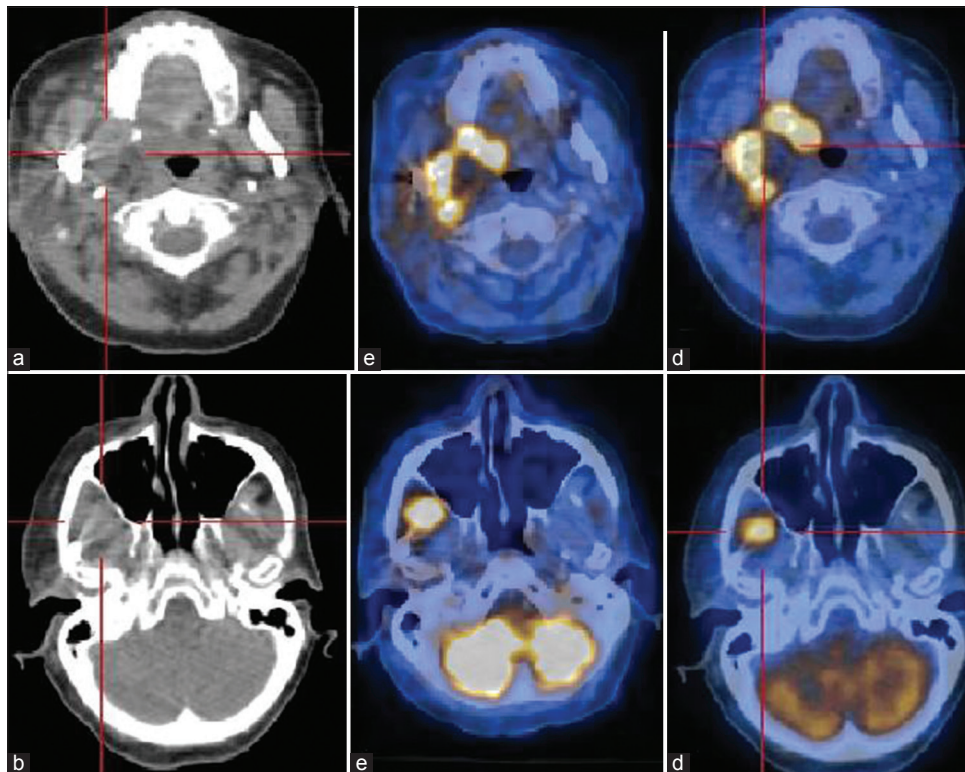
(a) Abnormal increased fluorodeoxyglucose (FDG) uptake noted in the soft tissue in the masticator space with early image (e) with a maximum standard uptake value (SUV) 8.4, retention of tracer in delayed image (d) with maximum SUV max 11.4. (b) Abnormal increased focal FDG uptake noted in infra-temporal fossae (SUV max early (e) = 8.0 and delayed (d) = 9.2)
